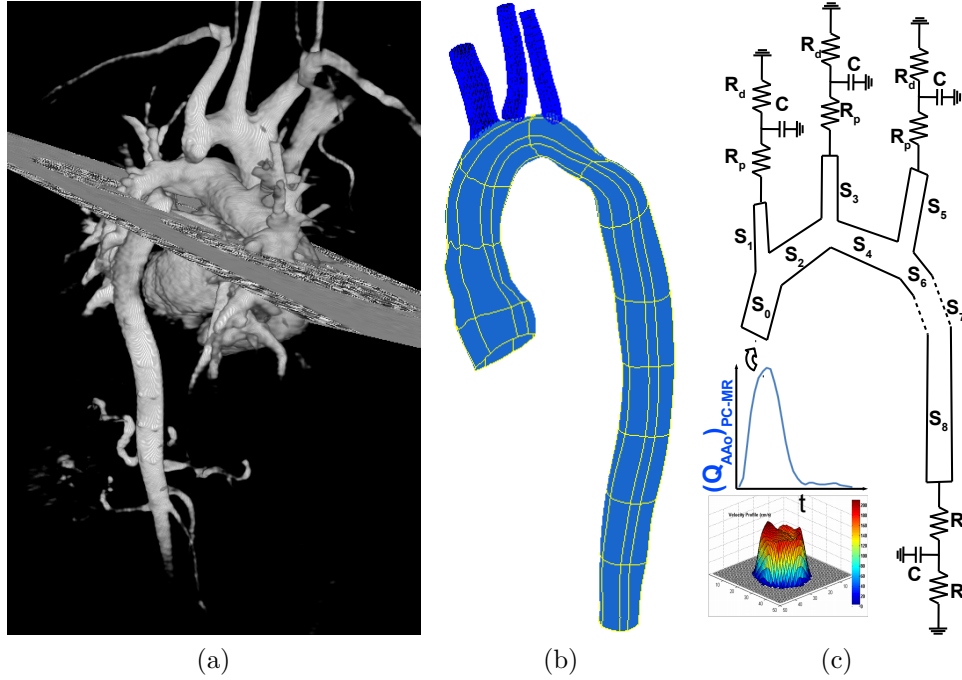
a) Standard CoA MR exam with pair of images: 3D MRA and flow encoded 2D+t PC-MRI. b) Combined surface of segmented lumen of thoracic aorta and trunk of main branches. c) Semantic view of arterial tree with discrete axisymmetric segments and terminal boundary conditions.
